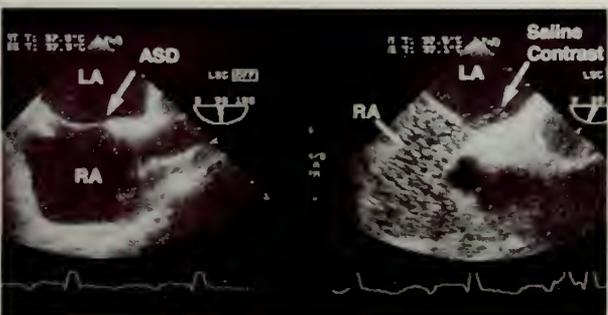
A small interatrial septal defect (ASD) is visualized on transesophageal echocardiography (left panel). The defect is in the thin portion of the interatrial septum (arrow) between the left atrium (LA) and right atrium (RA). Right panel, There is evidence of right-to-left shunting during a Valsalva maneuver, with agitated saline solution administered to an arm vein appearing first in the RA, then crossing the defect into the LA (arrow).
